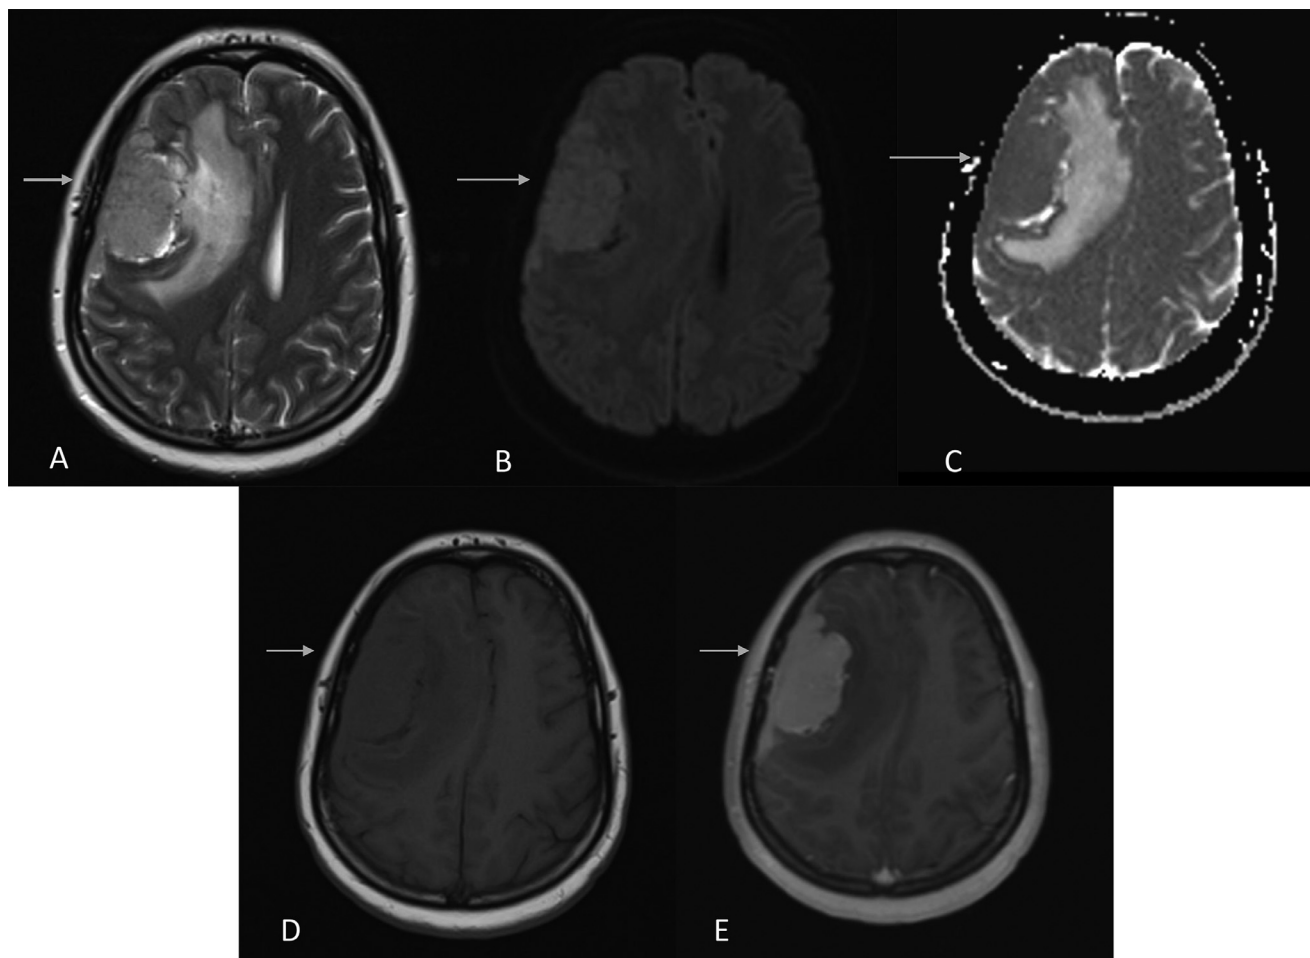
Multi-axial multisequential MRI brain showing A right frontal lesion with surrounding edema. The lesion appears iso-intense to the gray-matter in T1 (D) and T2 (A), with no diffusion restriction in DWI (B) and ADC (C) sequences with avid enhancement in T1 postcontrast (E).
